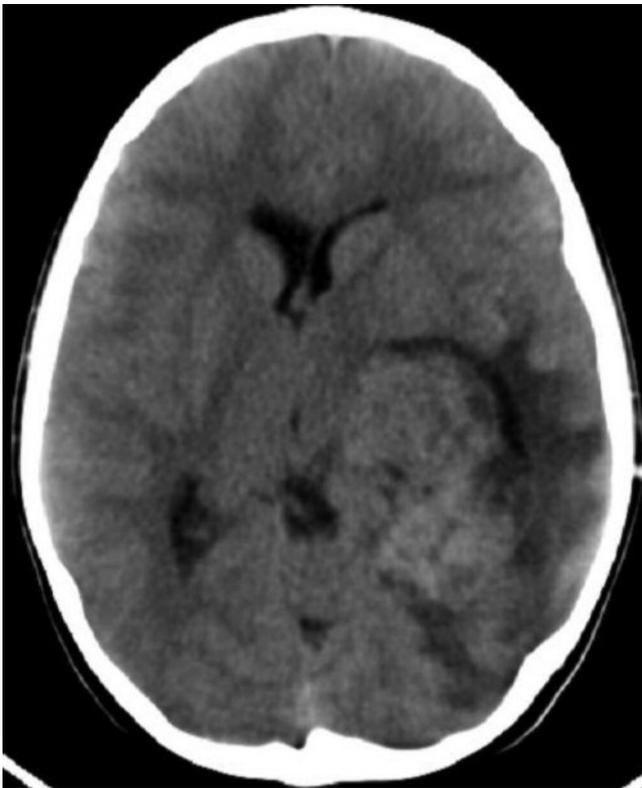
Preoperative computed tomography showing a solid, slightly hyperintense, microcystic intraventricular lesion.
